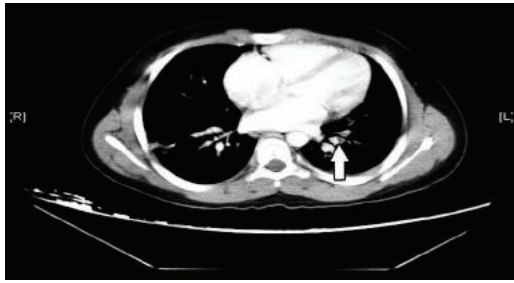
Spiral computed tomography of the chest demonstrating a segmental and sub-segmental filling defect of the left lower lobe artery.
